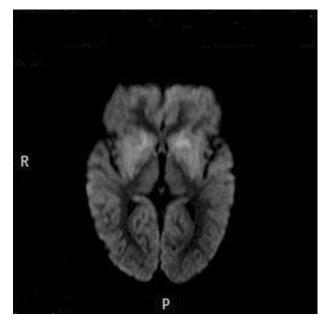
MR imaging in the first 24 h after acute ipoxic–ischaemic brain damage. Axial apparent diffusion coefficient map shows a reduced ADC value (0.41) in posterior putamen and globus pallidus, and a high ADC value in anterior putamen and head of caudate nuclei (0.73), indicating the prevalence of T2 effect. The relatively high ADC value indicates chronic impairment of anterior portion of basal ganglia.
